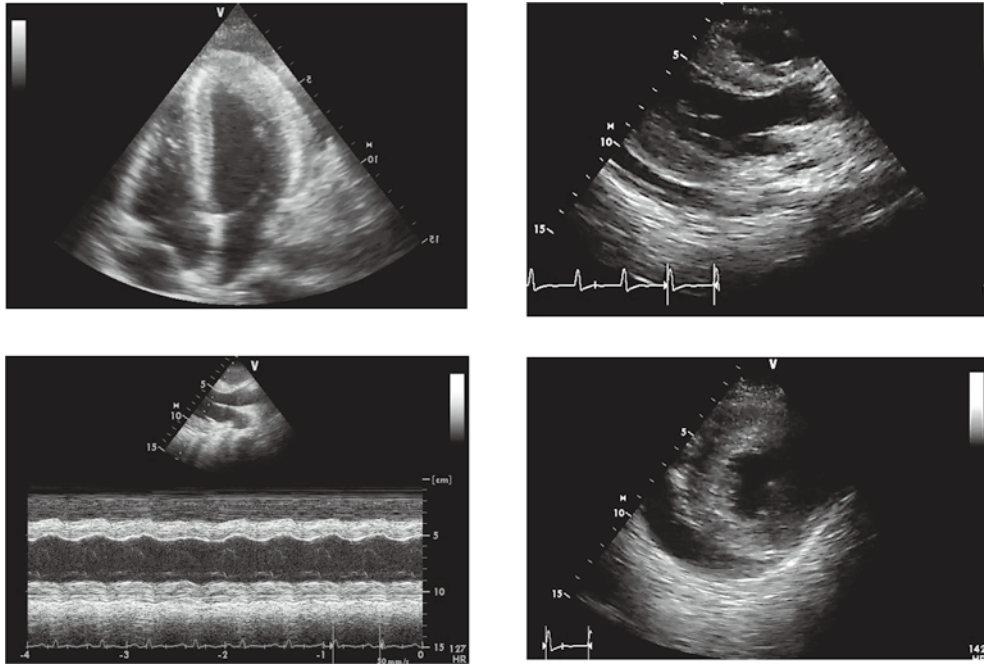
Echocardiography showed pericardial effusion with diastolic collapse of the right atrium, reduced left ventricular contraction and severe myocardial thickening on day 4 after BMT.
